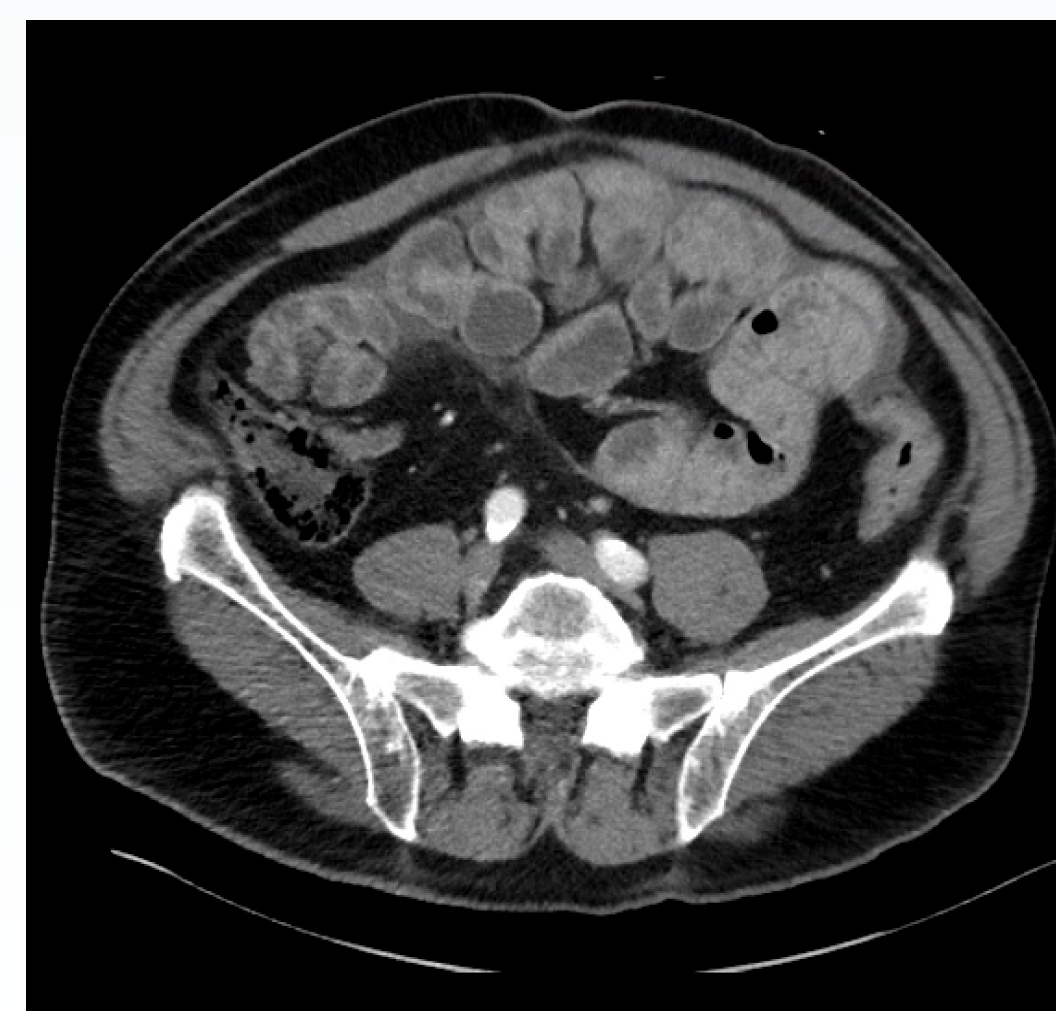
CT abdomen pelvis with IV contrast
